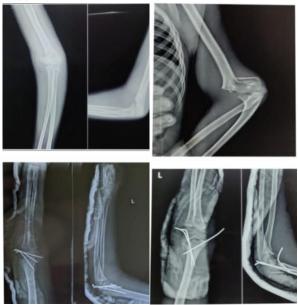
pre-op and post-op radiograph of lateral pinning VS crisscrossed k wire technique
